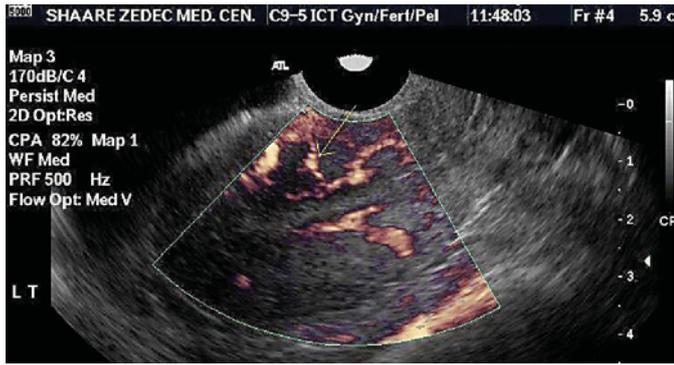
Radial artery and subendometrial flow by transvaginal sonography.
